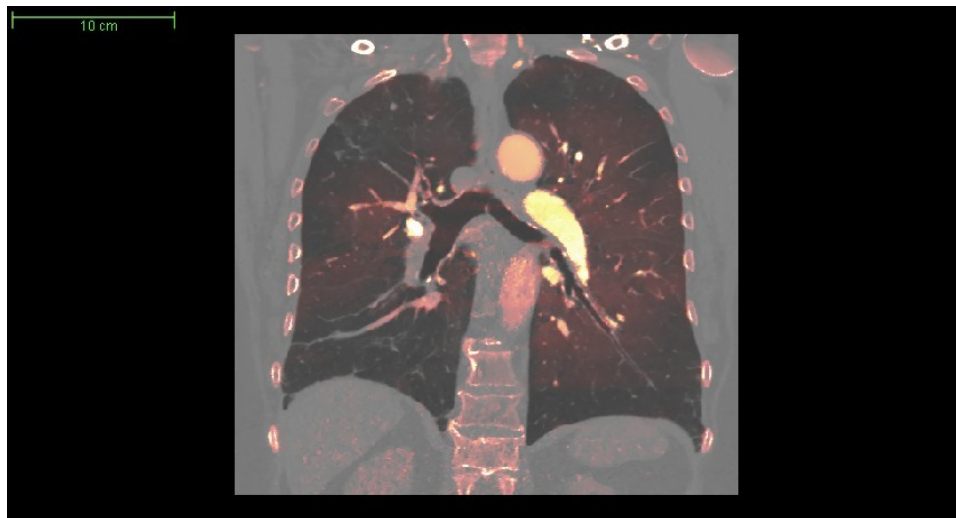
DE-CT scan with overlay of denoised iodine perfusion CT scan of a patient from our PH pilot study with suspect CTEPH.
